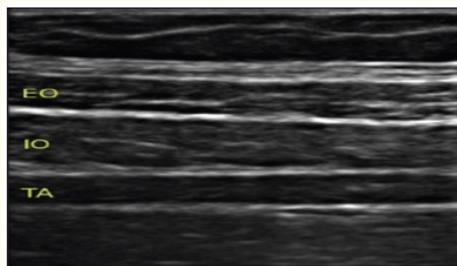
Ultrasound image of transversus abdominis muscle.
